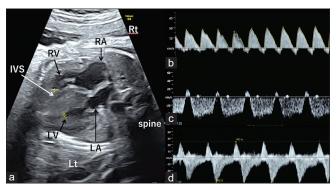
(a) Fetal heart ultrasound. (b) Reversed end-diastolic velocity in umbilical artery. (c) A wave reversal in ductus venosus. (d) Preload index in inferior vena cava. IVS: Interventricular septum, RV: Right ventricle, RA: Right atrium, LV: Left ventricle, LA: Left atrium
